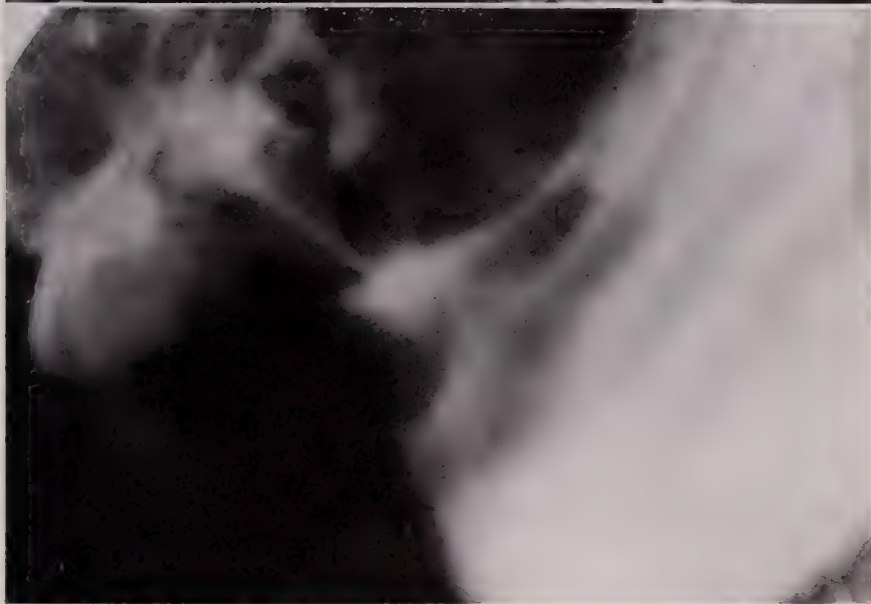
Case 1. X-ray showing the deformity and ulcer in the antral area and the normal duodenal bulb.
